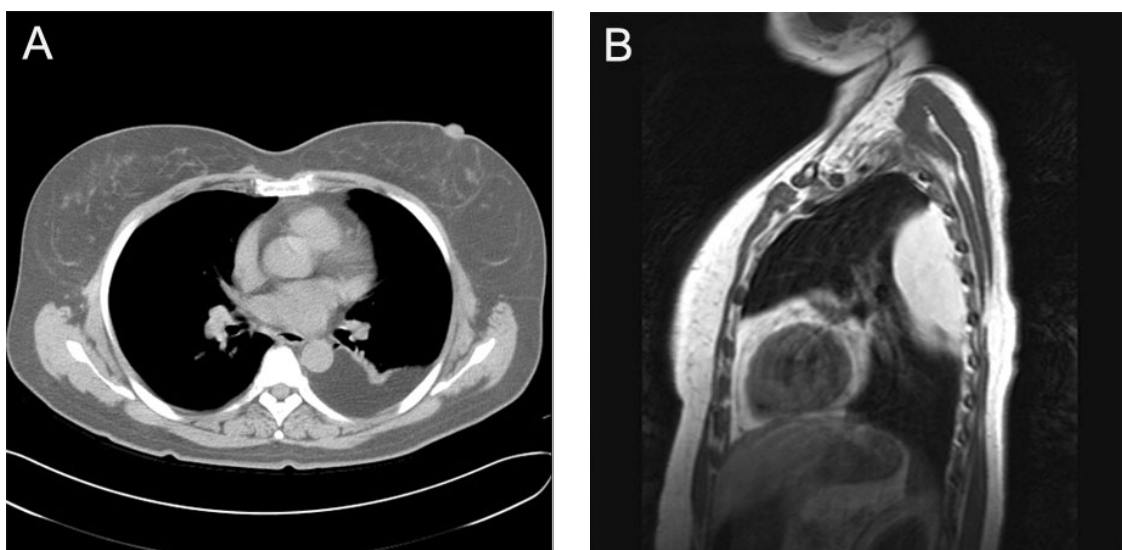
A. Chest CT scan shows left pleural based mass. The mean number of the mass after contrast is 100 HU, similar to adjacent fat tissue. B. Sagittal T2 weighted chest MRI shows high signal intensity lesion in upper lung field.
